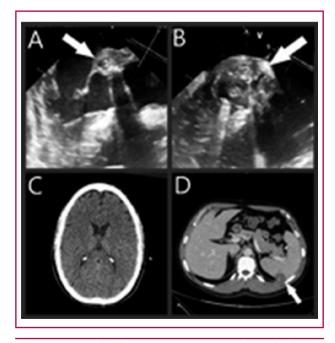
Preoperative images. A, B: Transesophageal echocardiography with prosthetic, periannular, and mitral valve involvement. C: Normal brain CT scan. D: Splenic embolism.
